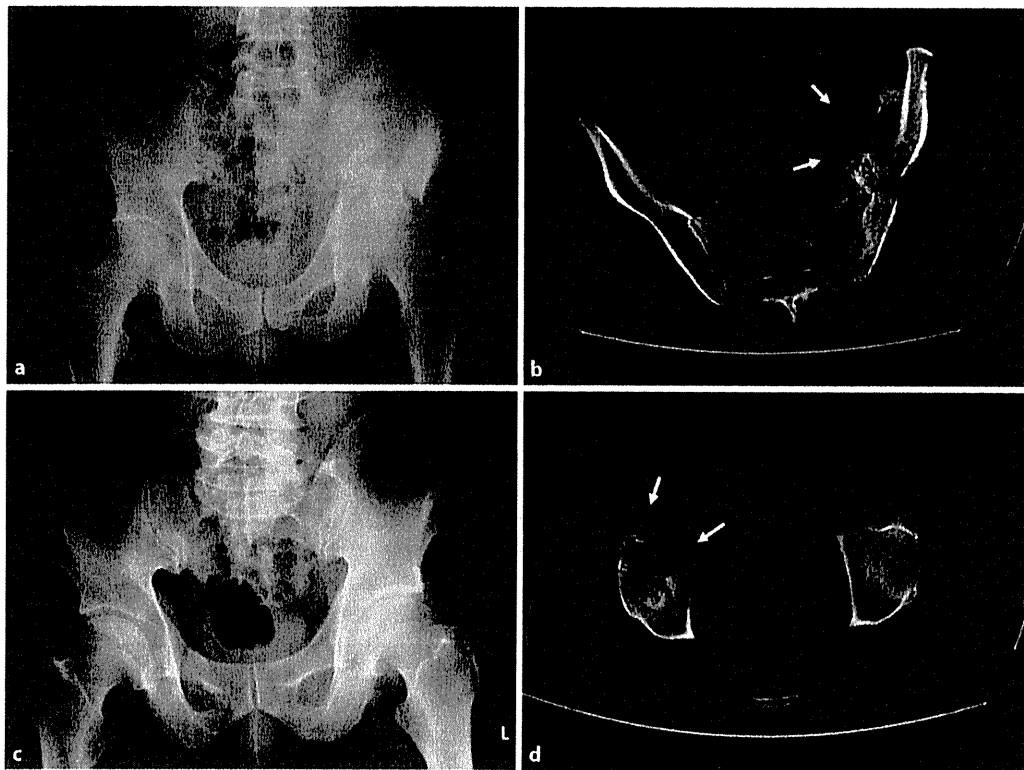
Radiographs and CT images at hospitalization. a Radiograph from June 2007. Osteosclerotic and osteolytic changes in the left iliac wing and a pathological fracture of the left acetabulum were observed in case 1. b CT imaging from June 2007. Expanded soft tissue around the left ileum can be recognized (arrows) in case 1. c In September 2006, radiography showed an osteolytic change in the right acetabulum in case 2. d CT image from September 2006 shows a moth-eaten pattern of destruction of the anterior part of the right acetabulum and expanded soft tissue (arrows) in case 2.
